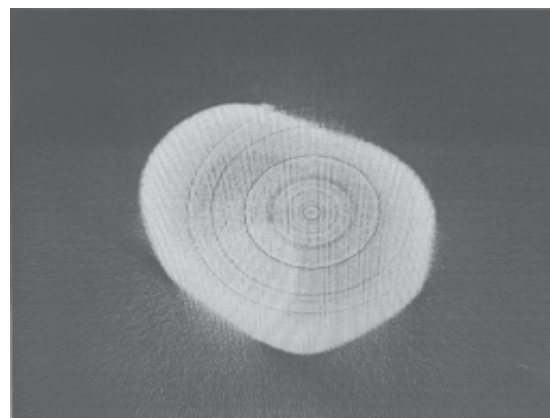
Micro CT validations
